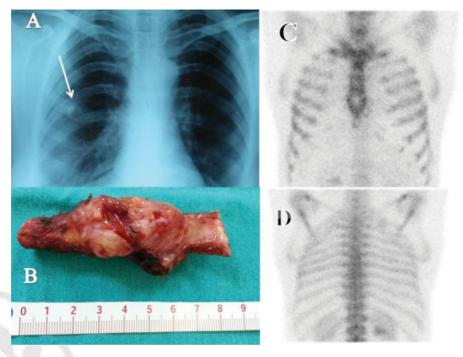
(A) A 50-year-old woman's chest X-ray after 9 months of her first admission shows an expansion and calcification on the costochondral junction of the right third rib (arrow). (B) In the same patient, excisional biopsy of the rib was done and the pathological examination was osteochondroma. (C) The anterior view of the preoperative bone scan of the same patient shows no radioactivity uptake in the ribs. (D) The posterior view of the preoperative bone scan of the same patient shows no radioactivity uptake in the ribs.
